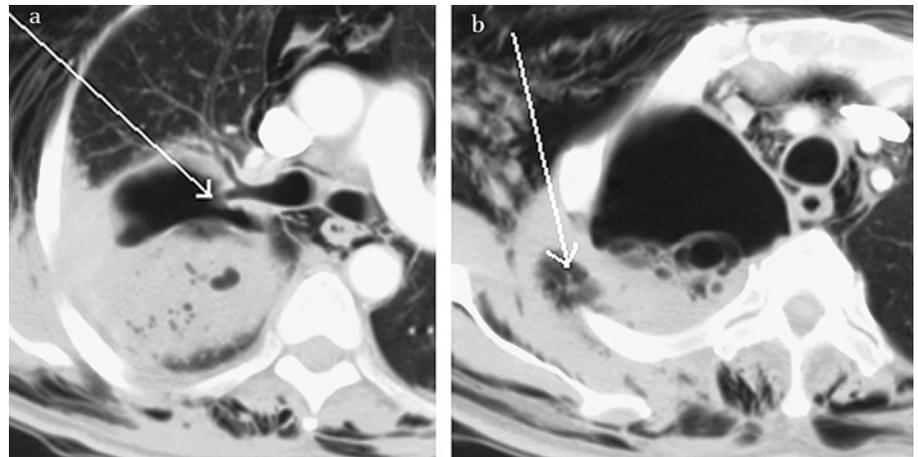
CT scan of the chest showing a cavitary lesion in the upper lobe of the right lung, communicating with the posterior segmental bronchus of the right upper lobe (arrow in a), with rupture into the chest wall (arrow in b). See Images in *Thorax*, page 280
